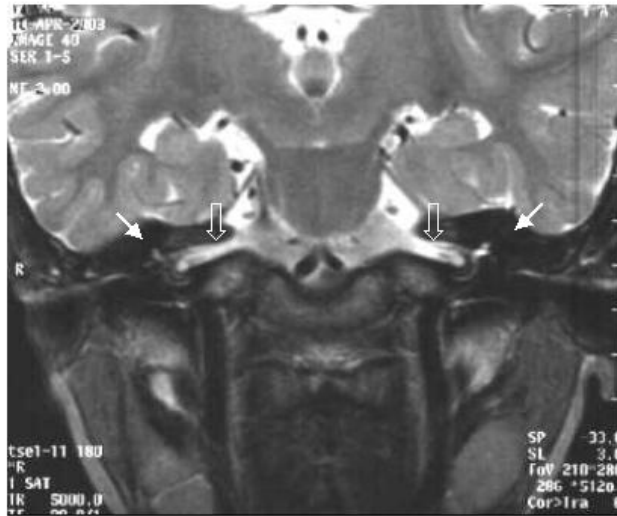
A coronal T2-weighted MRI (case 2) shows hypointensity of the labyrinthine structures bilaterally.
